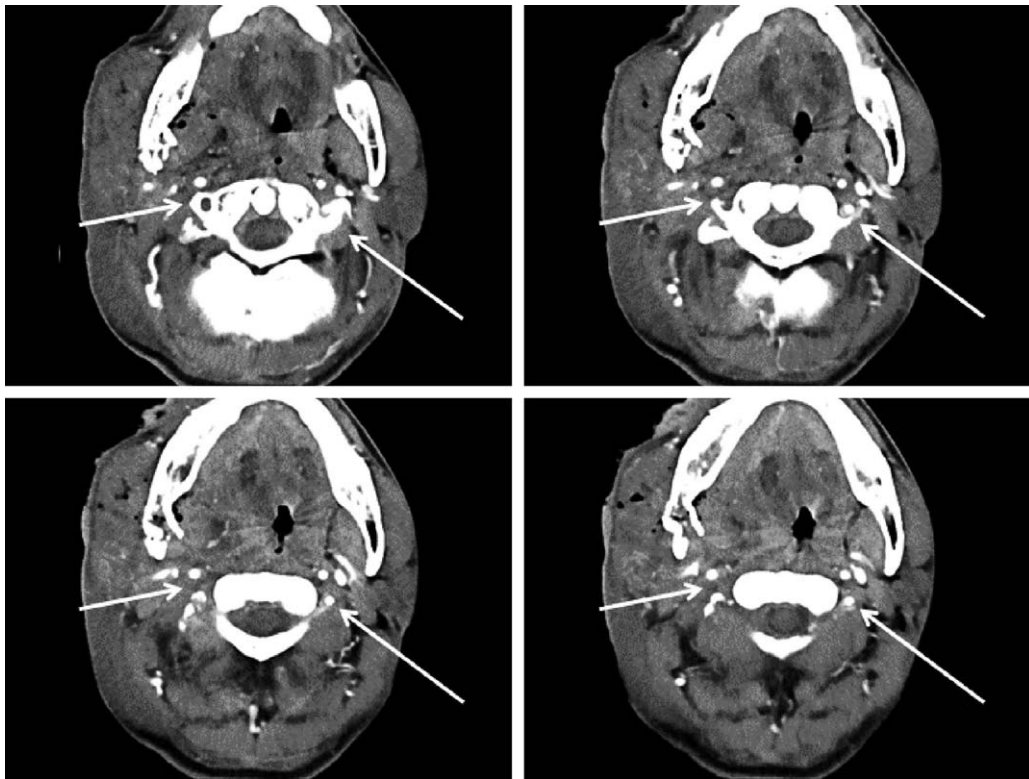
Right vertebral artery occlusion observed at the portion of the fracture of the atlas on CT angiography.
